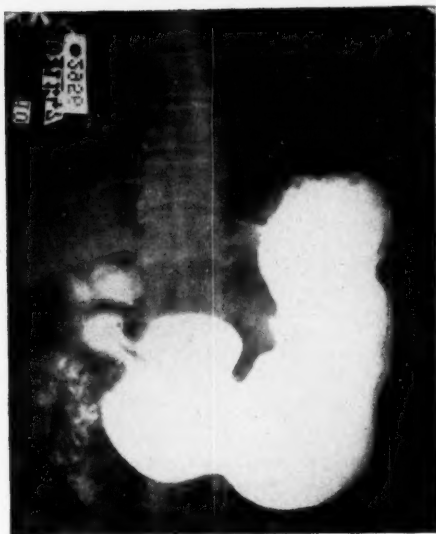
Roentgenogram of stomach in Fig. 5 after eight weeks of medical treatment, showing only very small crater on the lesser curvature.
